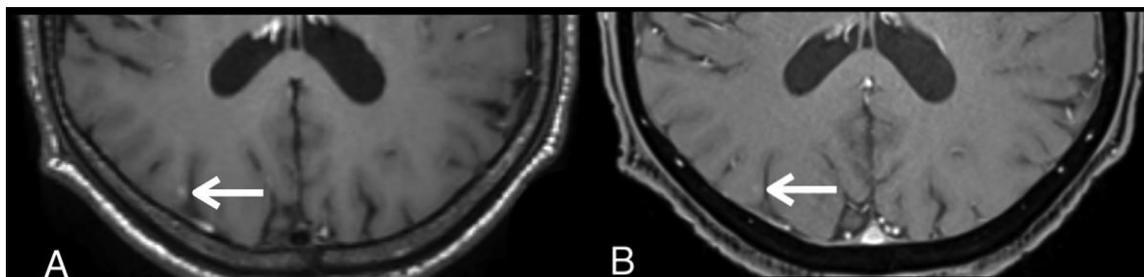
A 58-year-old lung cancer patient with a brain metastasis in the right occipital lobe (white arrow) that was missed by readers on contrast-enhanced 3D T1-weighted VIBE on a separate reading. Axial contrast-enhanced 3D T1-weighted SPACE (A) shows higher contrast enhancement compared with axial contrast-enhanced 3D T1-weighted VIBE (B).
